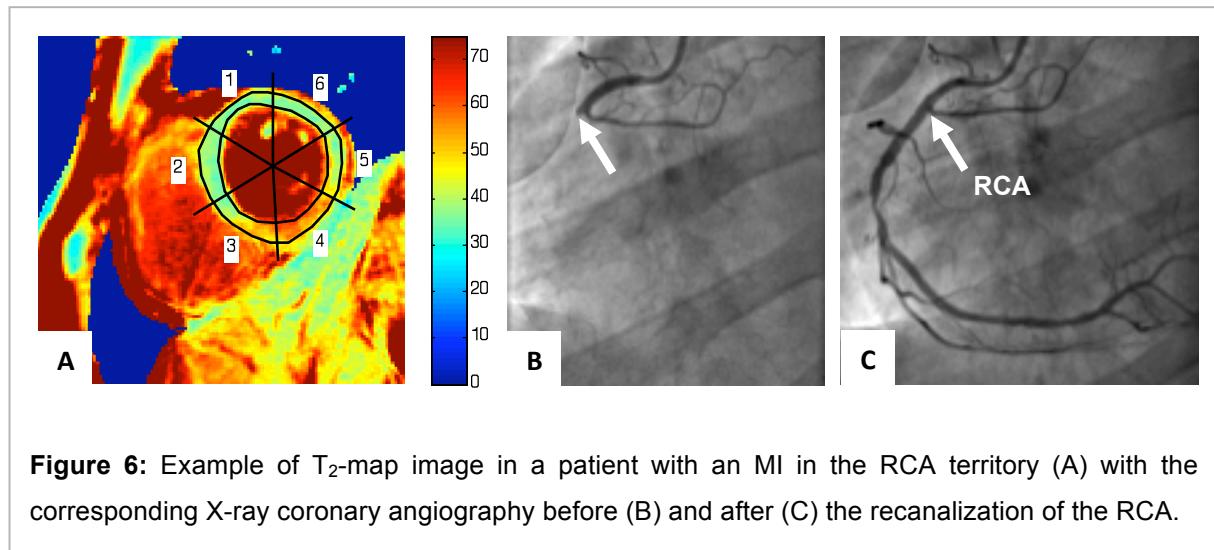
Example of T_2 -map image in a patient with an MI in the RCA territory (A) with the corresponding X-ray coronary angiography before (B) and after (C) the recanalization of the RCA.
